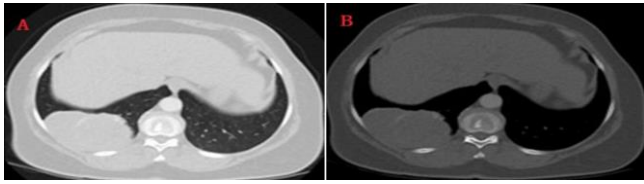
A hypodense mass lesion measuring approximately 8.5x6 cm was observed on computed tomography parenchyma window views (a) and mediastinal window views (b) in the basal part of the right hemithorax, at its widest point
